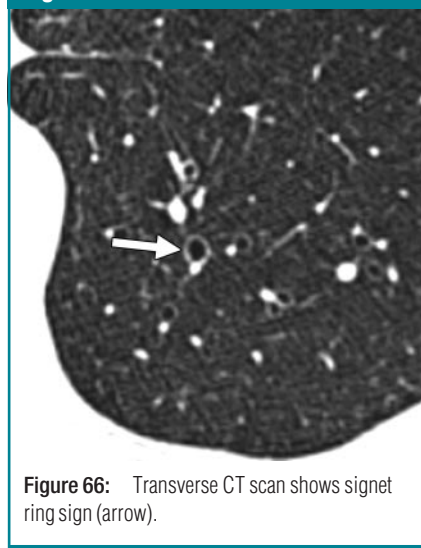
Transverse CT scan shows signet ring sign (arrow).
